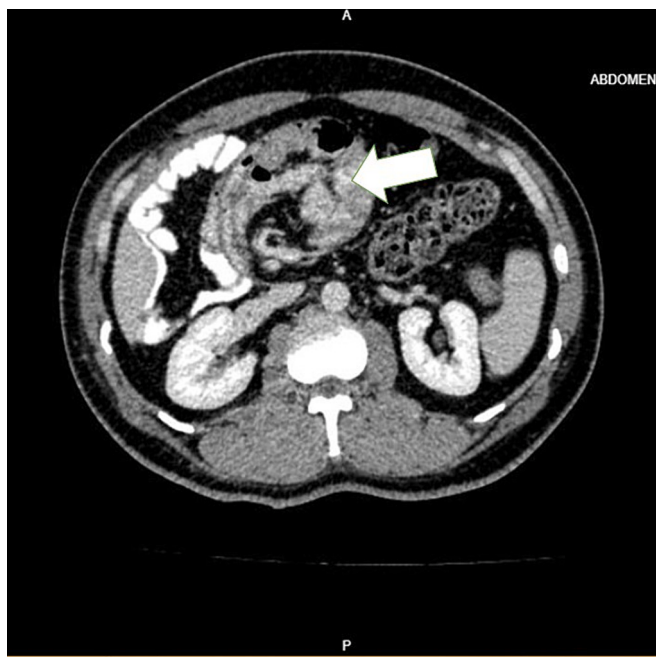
Double contrast axial CT scan of the patient revealing multiple dilated proximal-mid small bowel loops in small bowel obstruction. The cluster of the small intestine is seen in the lower part of the third part of the duodenum (arrow). The duodenum has yet to cross the midline.
